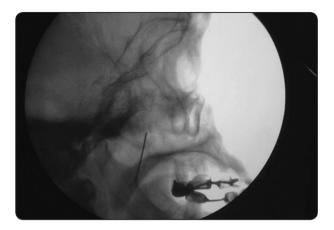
Radiograph showing lateral view of PRF needle at the pterygomaxillary fissure (course of maxillary nerve).
